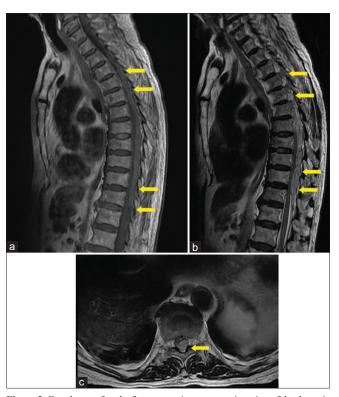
Four hours after the first magnetic resonance imaging of the thoracic spine. (a) T1-weighted imaging sagittal view revealing a hypointense lesion in the dorsal epidural space from T3–T11, (b) T2-weighted imaging sagittal view revealing the same isointense lesion, (c) T2-weighted imaging axial view revealing isointense lesion occupying the spinal canal and compressing the spinal cord
